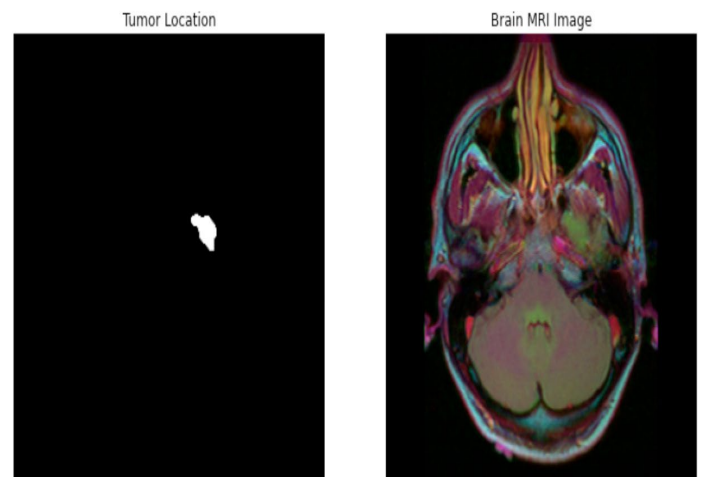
Tumor Location and Brain MRI Image
